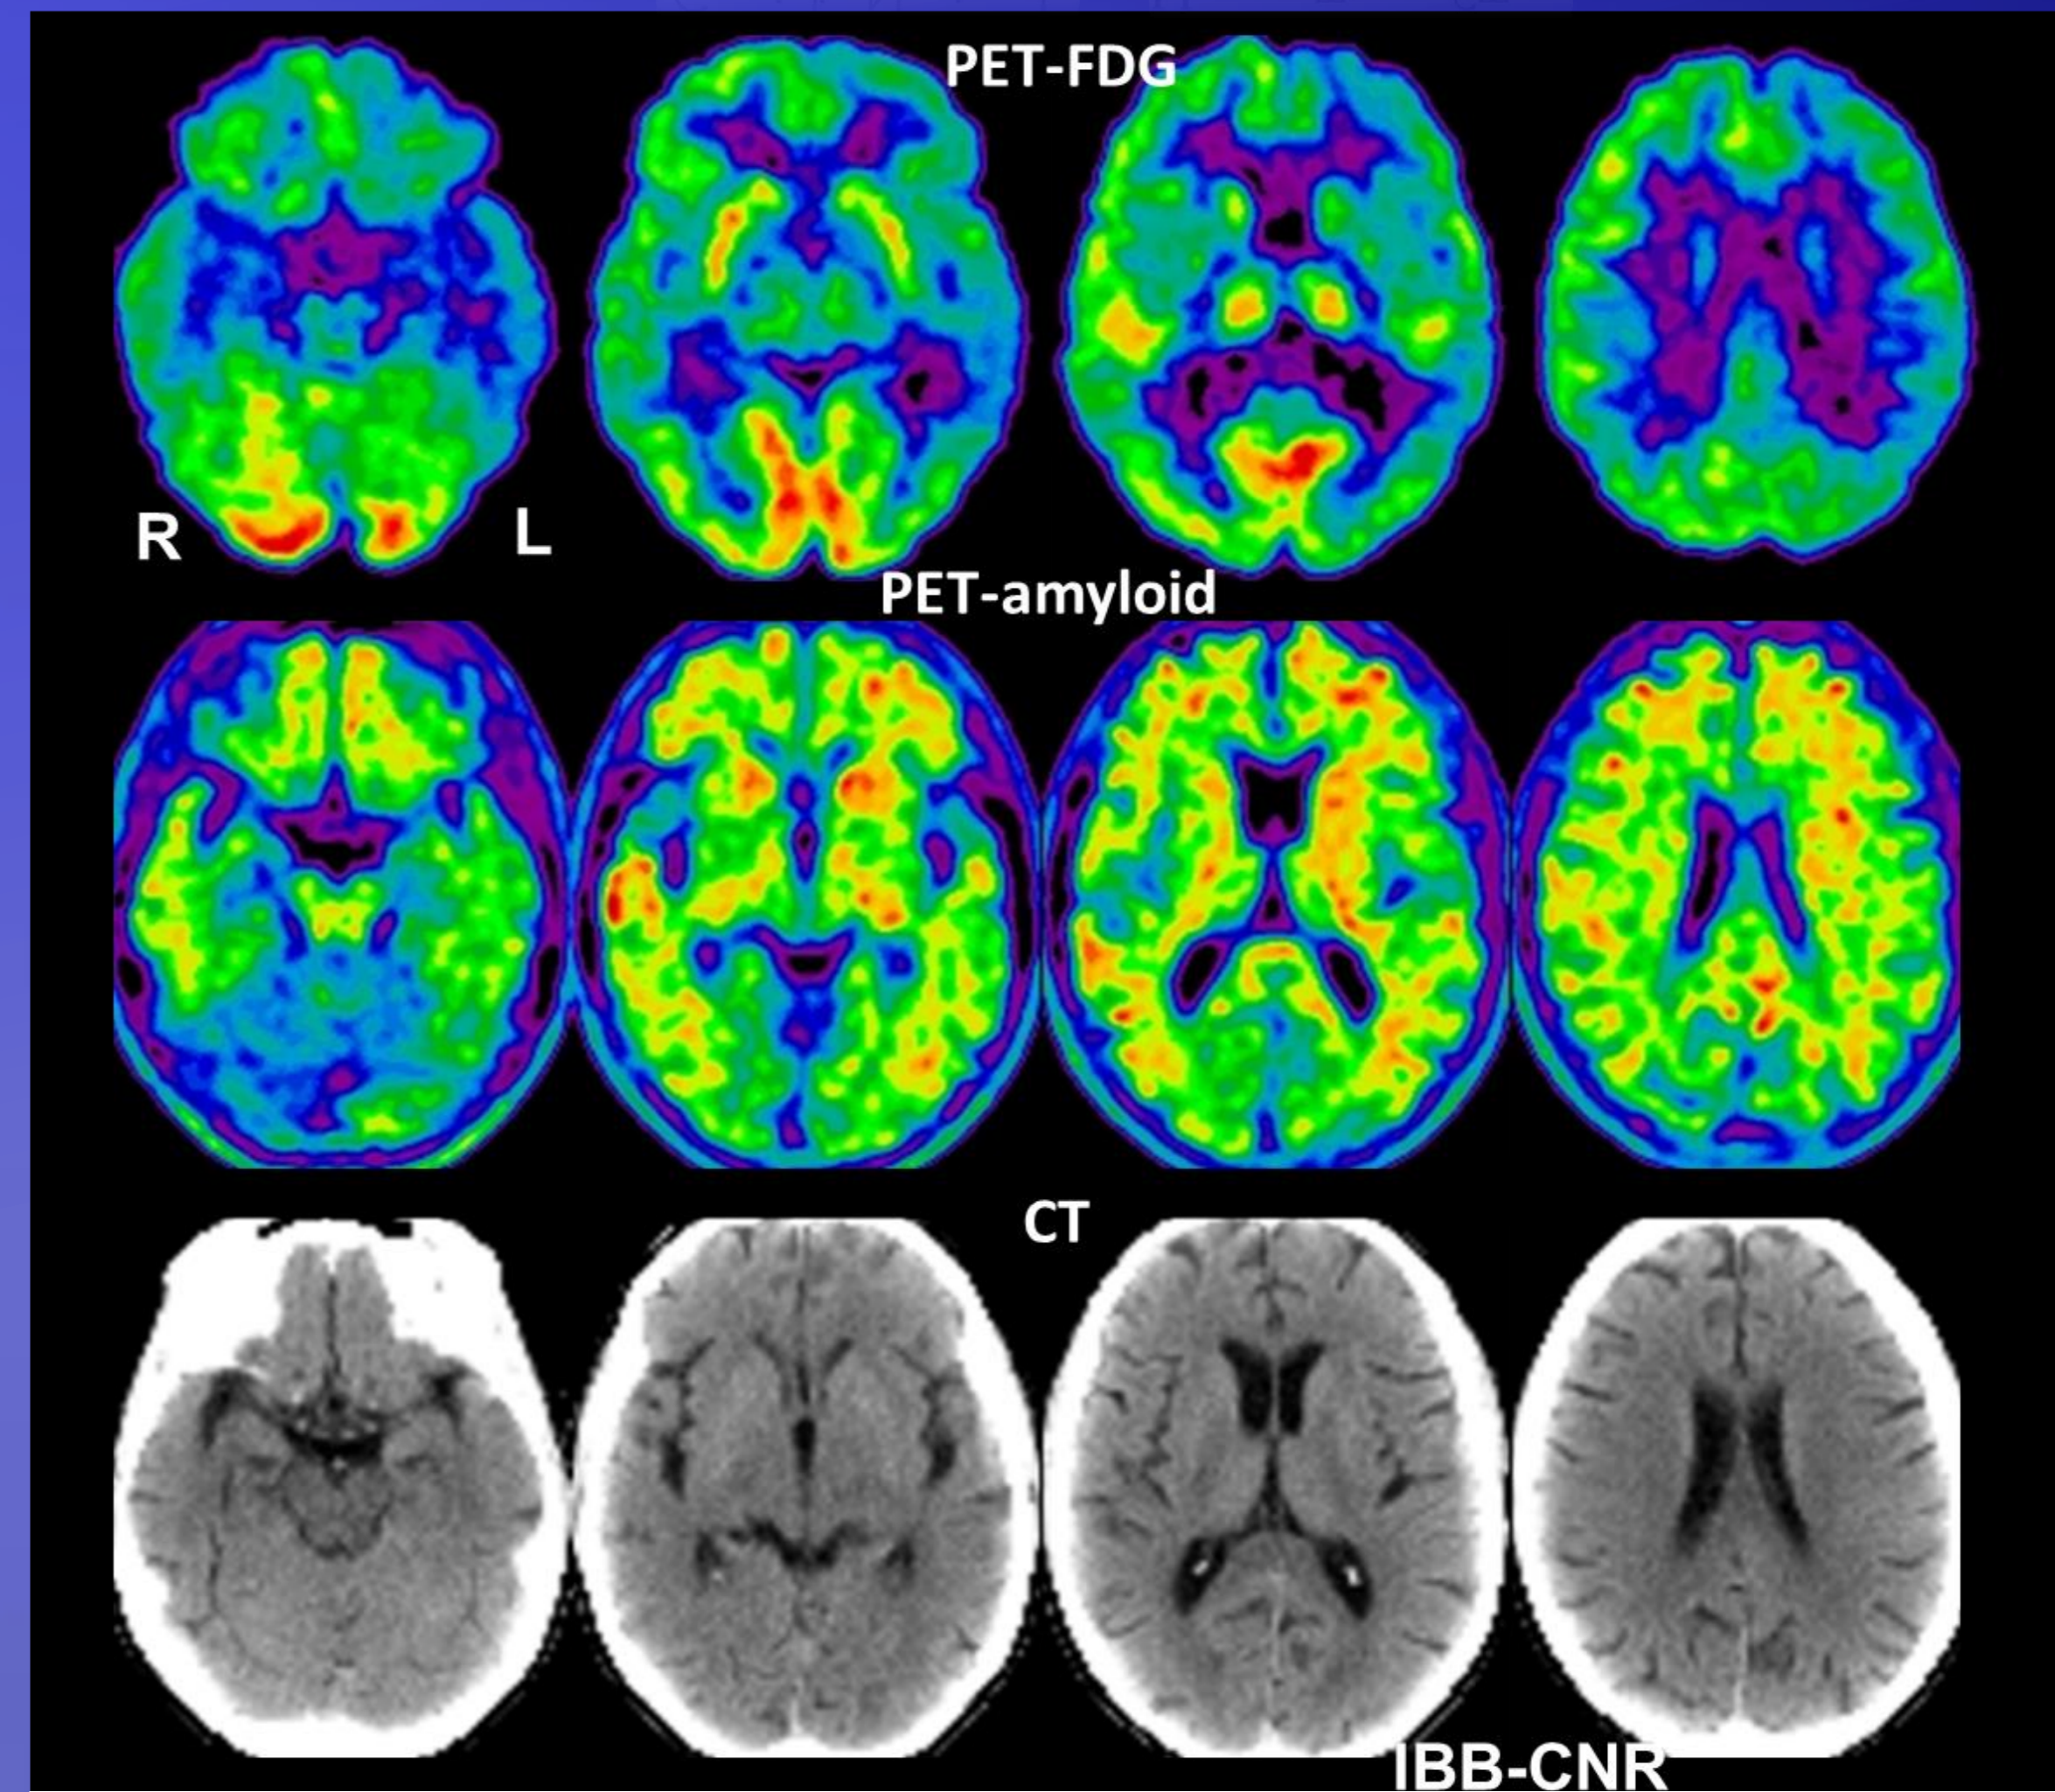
PET-FDG (top), ¹⁸F-florbetapir amyloid PET (middle), CT (bottom)
